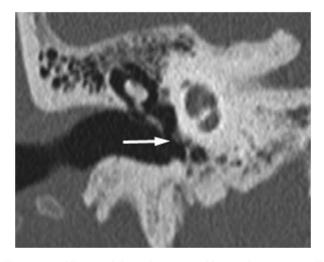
CT scan of the right temporal bone, showing a small tympanic paraganglioma on the cochlear promontory (arrow).
